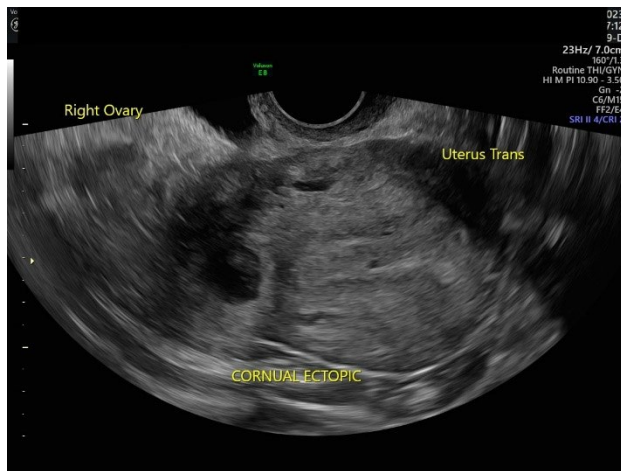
Ultrasound image
